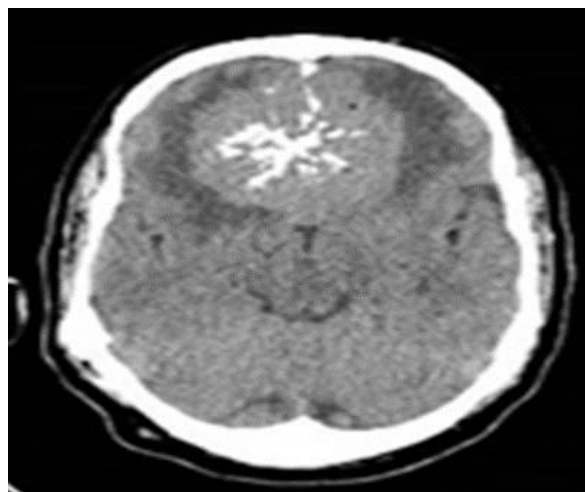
Axial pre-contrast cranial CT scan at the level of the midbrain, showing a well-defined, oval shaped isodense to hyperdense, located in the floor of the anterior cranial fossa with central areas of calcification within it.
